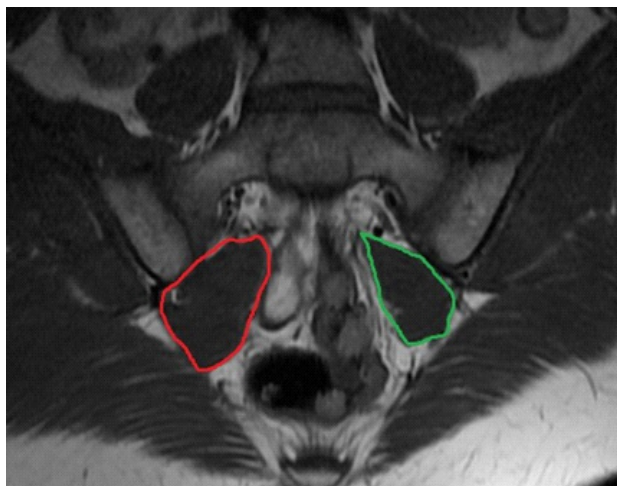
Coronal T1 WI MR image shows right piriformis muscle (bordered with red) is thicker than left (bordered with green). There is no pathologic signal on both muscles.
